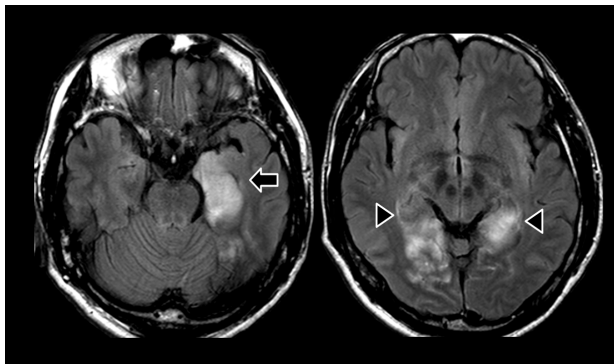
Brain magnetic resonance imaging (MRI) at admission. Fluid-attenuated inversion recovery magnetic image revealed hyperintensity in the left medial temporal (arrow) and bilateral occipital cortices (arrow heads).
